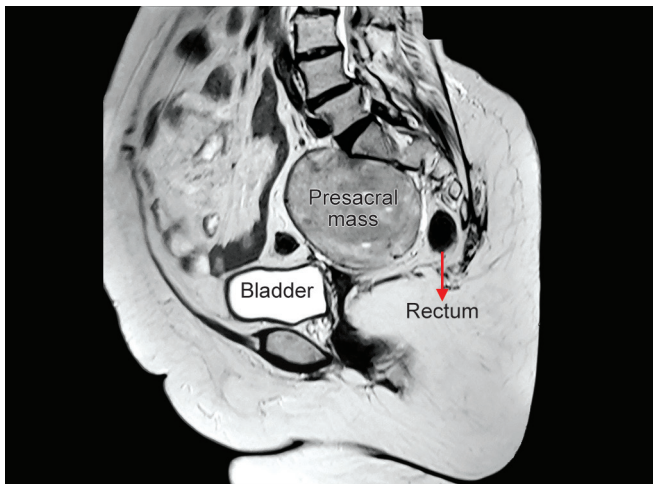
MRI showing presacral tumor
